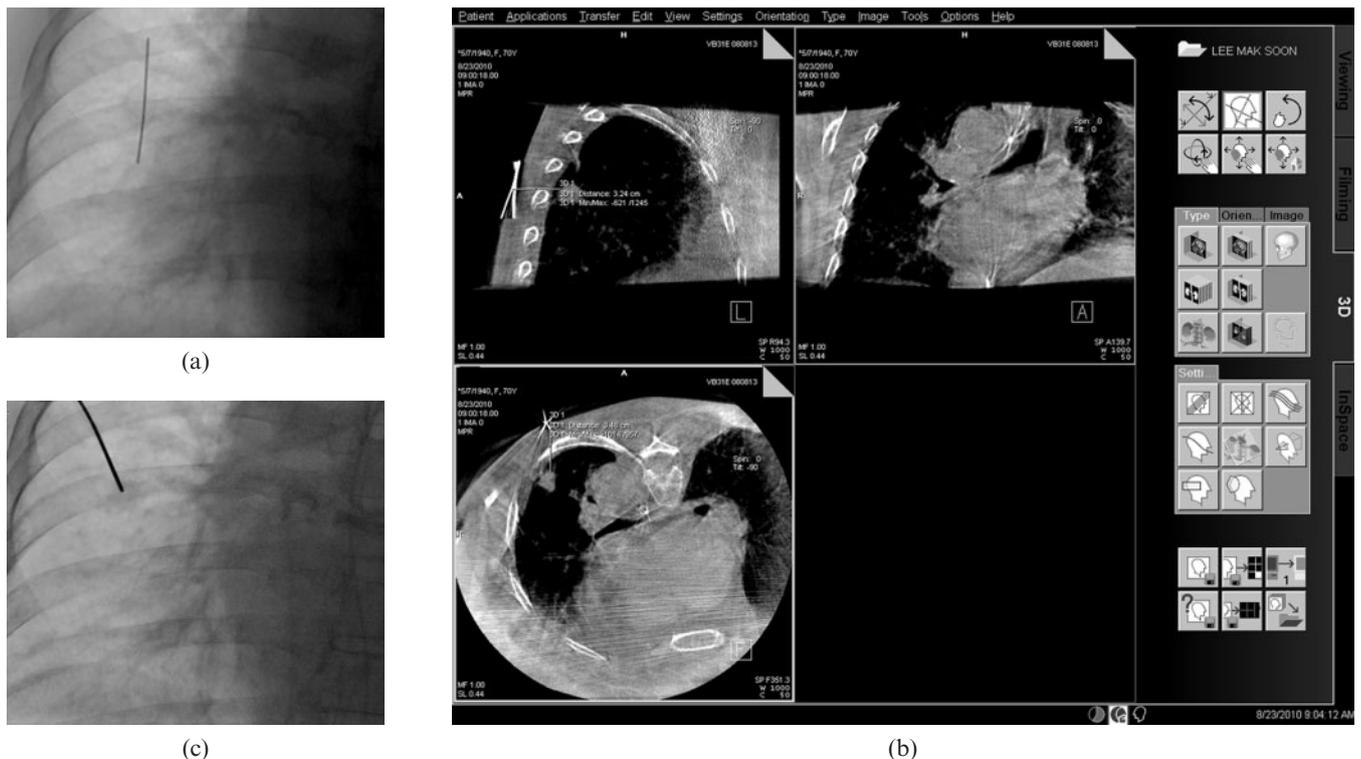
C-arm cone-beam CT-guided transthoracic needle biopsy in a patient with a nodule in the right upper lobe. (a) For the first step, a metallic line marker was attached to the patient's skin, covering the anticipated entrance point of the needle, under fluoroscopy guidance. (b) CT scan was performed and the exact entrance point and puncture depth of needle were determined based on the analysis of multiplanar reformation images on a computer workstation. (c) The last step involved a transthoracic needle biopsy with a 18-gauge automated cutting needle under fluoroscopy guidance.
